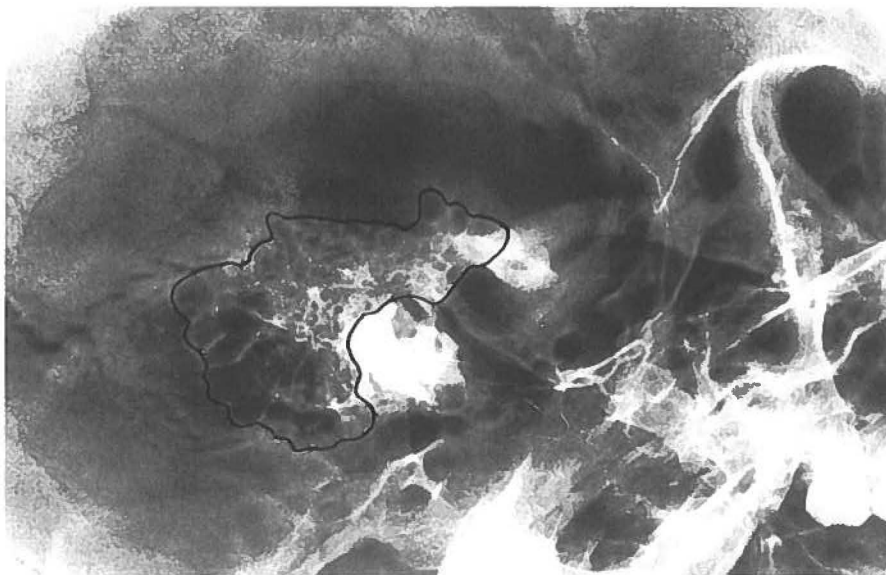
X-ray of the left side temporal bone in a cranium. The pneumatized cell system is outlined. The area size is normal.
